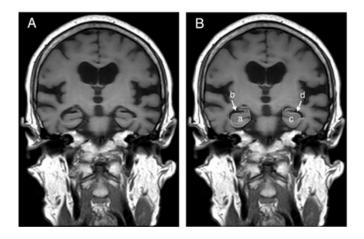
Analysis of hippocampal atrophy. In T1-weighted coronal images of MRI (A), areas in the hippocampus (a,c) and the cavity surrounding the hippocampus (b,d) were measured at the section at which the Monro foramen is seen (B). To normalize hippocampal size, the ratio of area in the hippocampus (a or c) against area in the hippocampus plus the surrounding cavity (a+b or c+d) was calculated
